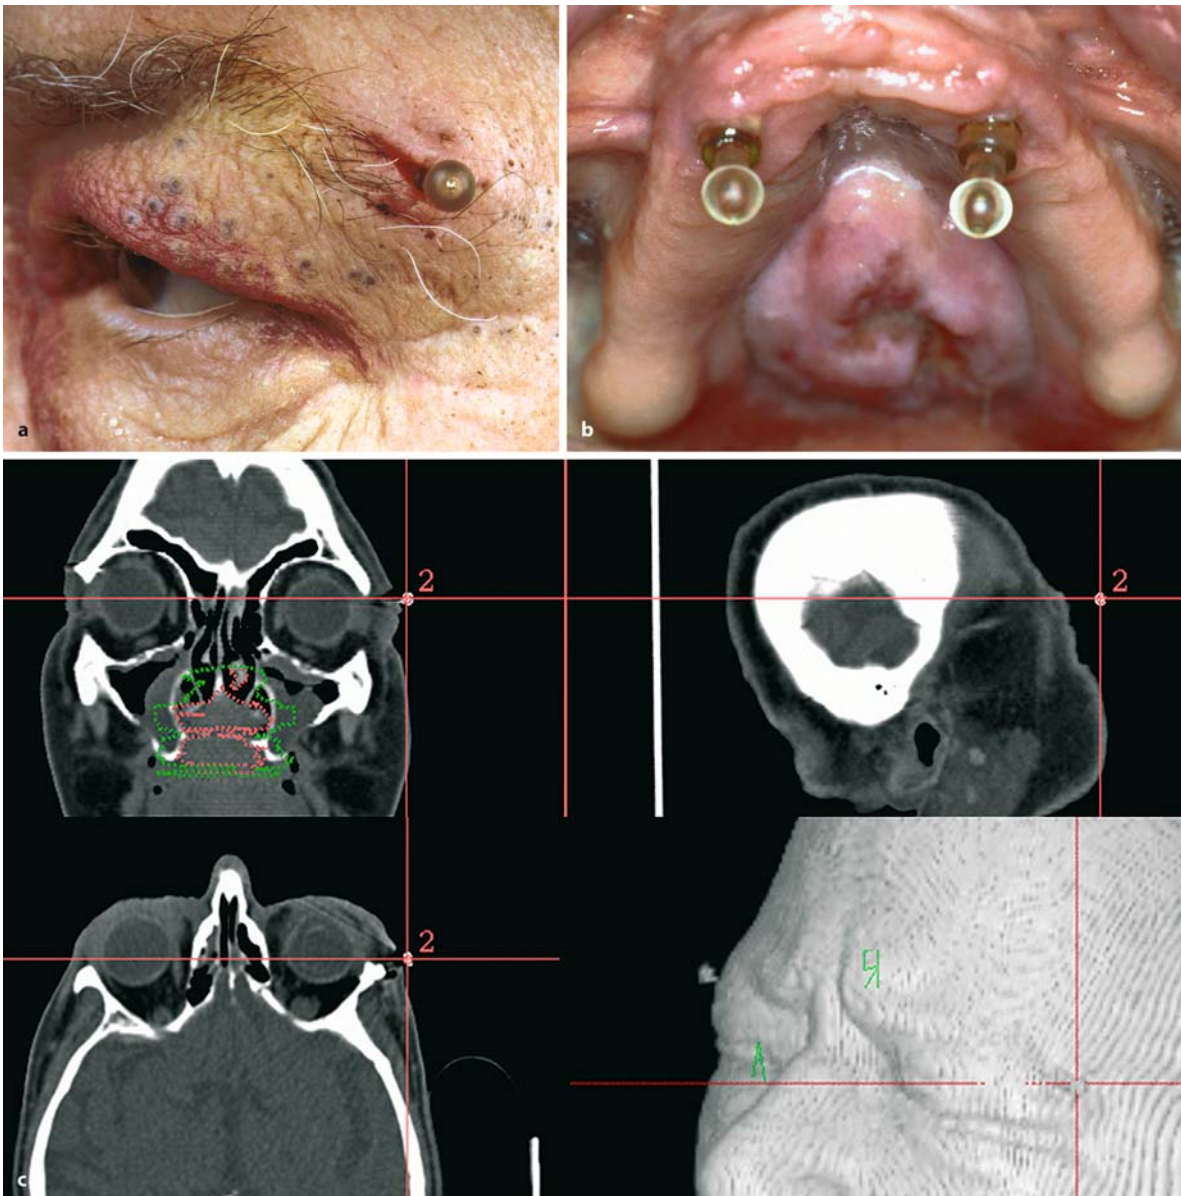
Clinical application of screw-based invasive registration. Markers placed extraorally (a) or intraorally (b) under local anesthesia are visualized in the CT data set and used as registration points (c)
